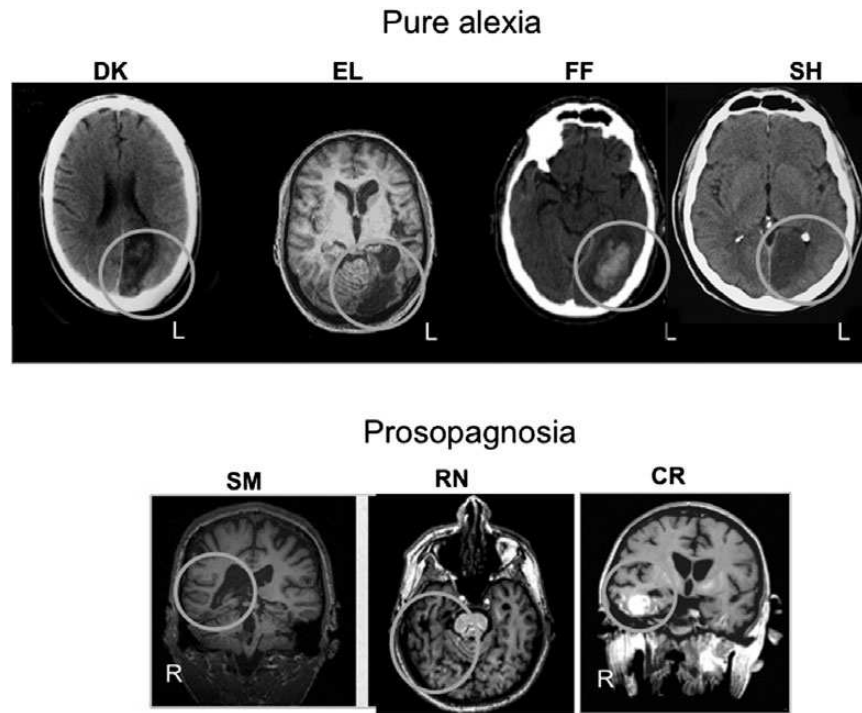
Representative axial slice from the MRI scan (1.5 or 3 T) of each of the 4 patients with pure alexia, all showing left occipitotemporal lobe involvement (top row) and a representative slice from the MRI scan of each of the prosopagnosic patients. Details regarding etiology of lesion and time since onset may be found in Methods section.
